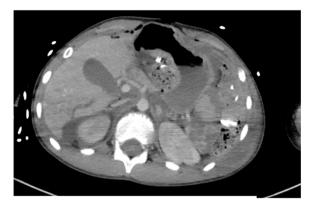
CT images showing liver laceration.
